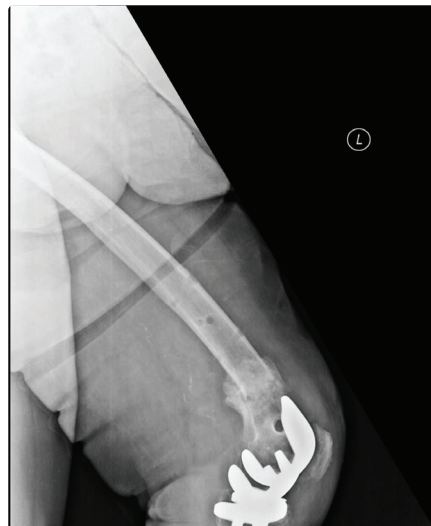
X-rays of the same patient showing an uncomplicated full bony healing.
